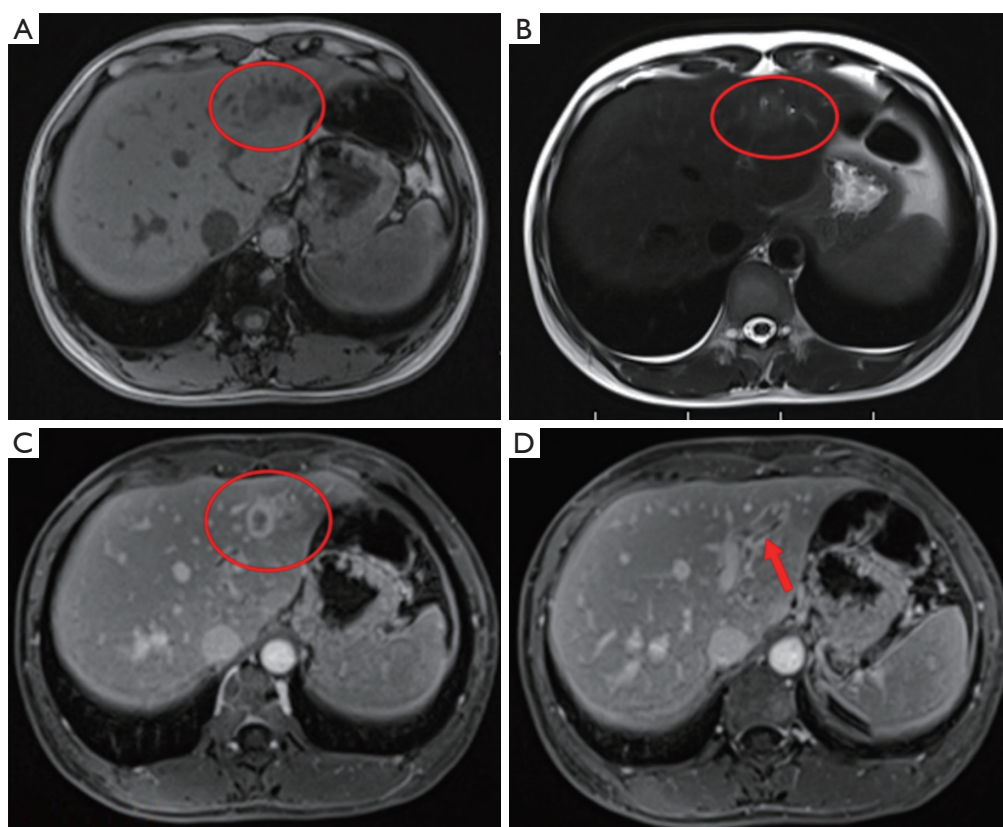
The red circles are lesions. MRI identified circular long T1 and T2 signals in the left outer lobe of the liver. The red arrow points to the lesion. The enhanced scan also depicts a ring-shaped delayed enhancement shadow along the bile duct and thickening of the adjacent bile duct wall. (A) T1WI; (B) T2WI; (C) T1WI+ contrast; (D) T1WI+ contrast. MRI, magnetic resonance imaging; T1WI, T1-weighted imaging; T2WI, T2-weighted imaging.
